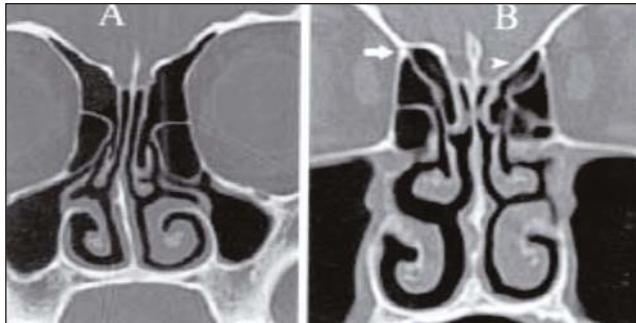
Coronal CT sinus scan showing A) symmetric ethmoid fovea on both sides and B) asymmetry of ethmoid fovea with low lying fovea on left side (arrow head)
